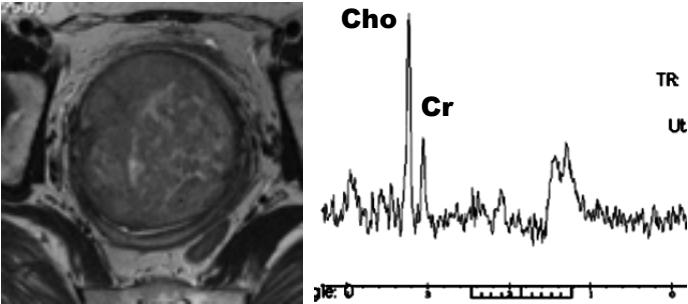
Cellular leiomyoma shows high signal intensity on T2-weighted image, and bimodal peaks of choline and creatine on MRS.
